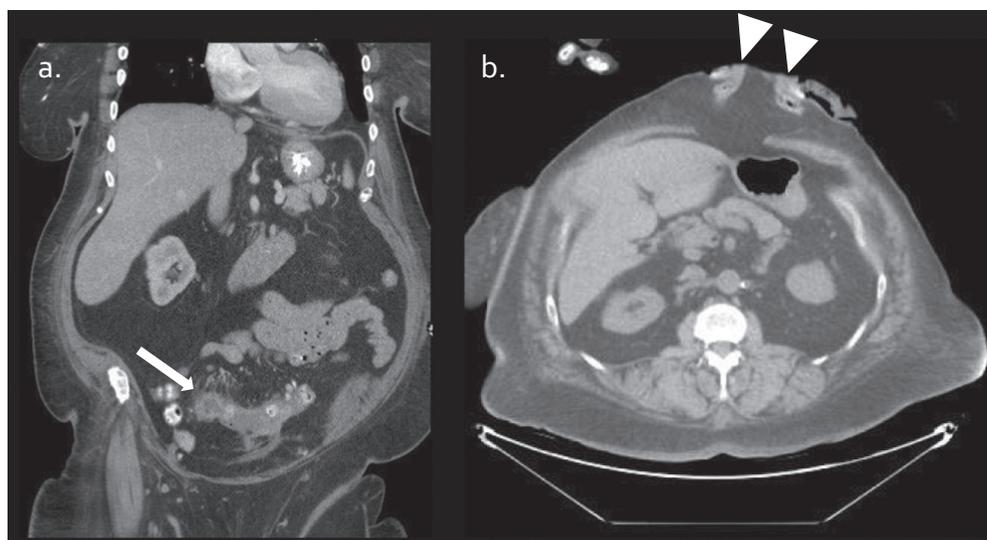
Double barrel colostomy: coronal (a) and axial (b) CT images in 75 y old morbidly obese female who was not a surgical candidate for sigmoidectomy underwent a double barrel colostomy for repeated episodes of diverticulitis. Sigmoid thickening and a small abscess (arrow) are seen. Note the stomas are slightly separated from each other (arrowheads).
